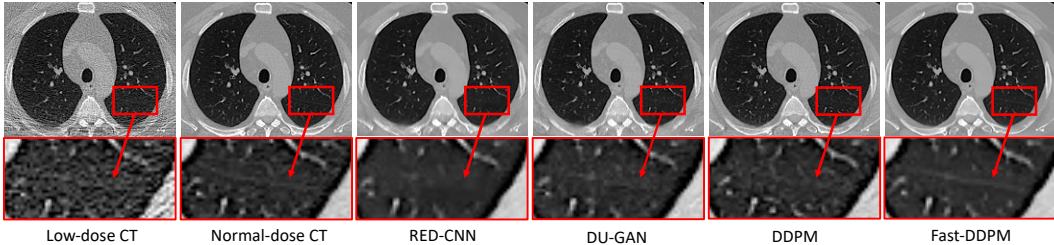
Qualitative results of the CT image denoising task.
